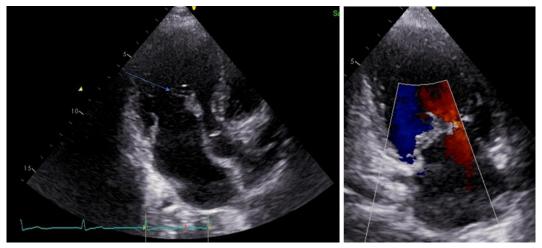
Mitral valve Libman-Sacks endocarditis in a patient with SLE. Transthoracic echocardiogram demonstrates a mobile mass of the mitral valve consistent with vegetation.
